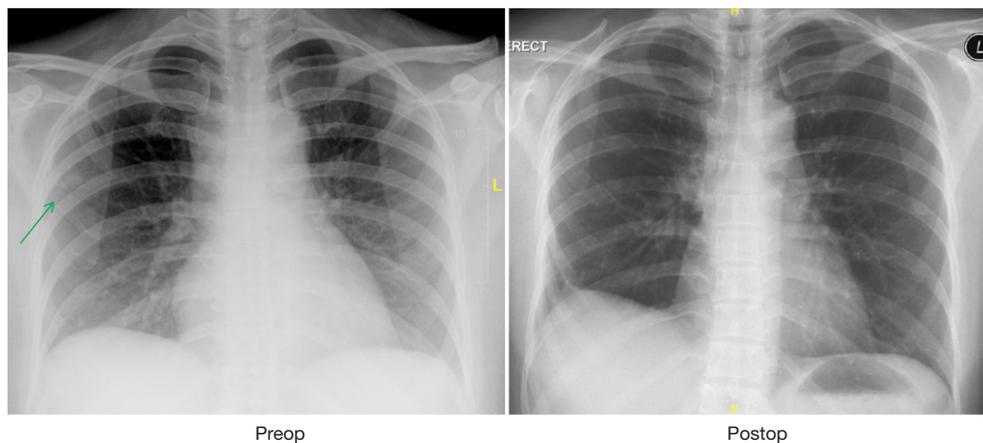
Chest radiograph of first UVATS lobectomy for lung cancer. UVATS, uniportal video-assisted thoracic surgery.
